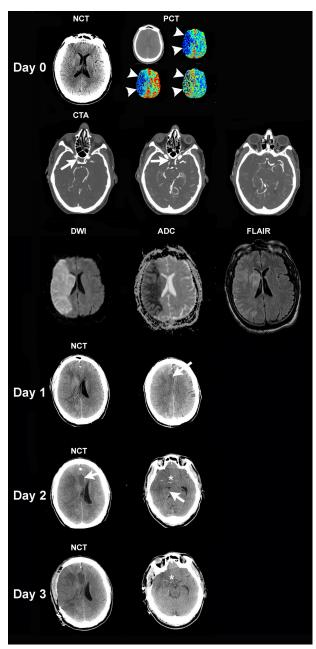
A 56-year-old male patient was admitted 5 hours after onset of right hemiplegia. Initial noncontrast computed tomography (NCT) showed slight effacement of the right lentiform nucleus but no hypodensity. A perfusion computed tomography (PCT) study obtained immediately after the NCT demonstrated a large area of hypoperfusion (prolonged mean transit time, decreased cerebral blood flow, and cerebral blood volume; arrowheads) in the right middle cerebral artery (MCA) territory, consistent with a large infarct core. The computed tomographic angiogram (CTA) revealed an occlusion of the right internal carotid artery (ICA) extending to the right MCA (arrows). A magnetic resonance image obtained shortly after the computed tomographic workup confirmed the PCT findings, namely a large infarct in the right MCA territory with restricted diffusion (bright signal on diffusionweighted images [DWIs] and dark signal on average diffusion coefficient [ADC] maps). Fluid-attenuated inversion recovery (FLAIR) images showed early abnormalities in the same distribution. Endovascular revascularization was not attempted because of the size of the infarct core on DWI. At day 1, follow-up NCT shows a frank hypodensity in the right MCA territory, with a suggestion of hemorrhagic transformation in the right basal ganglia.
